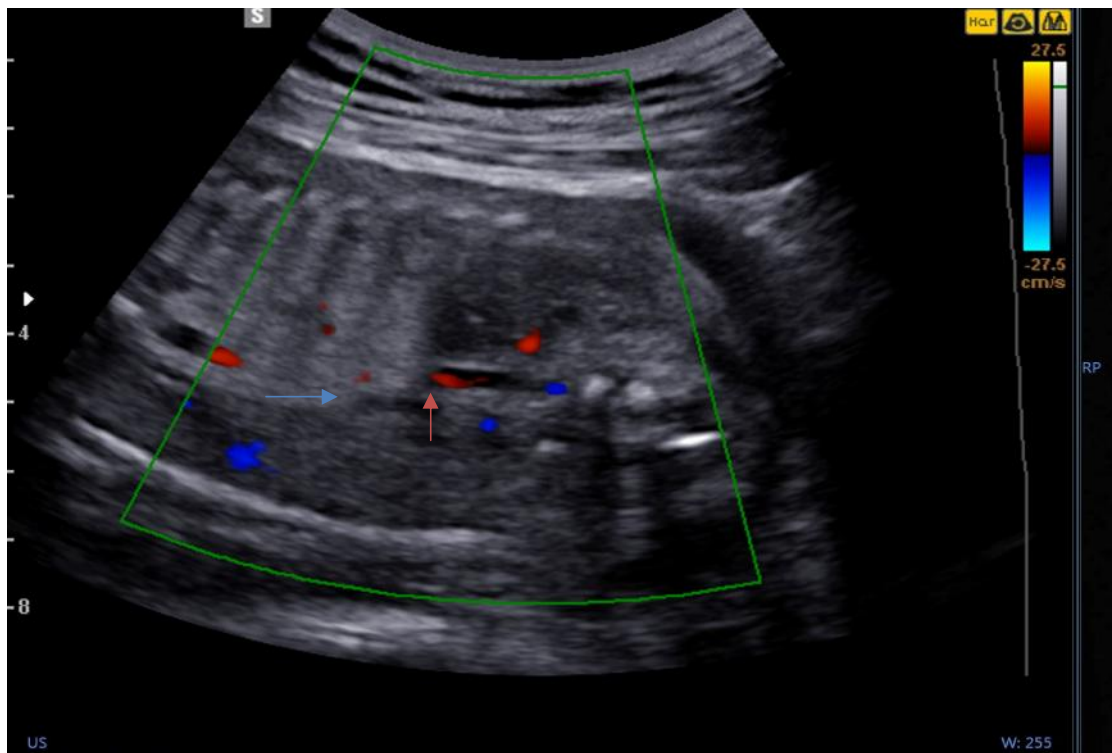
US prenatal color Doppler modality in which the vascularity of the pulmonary lesion from the aorta is observed (orange arrow).
